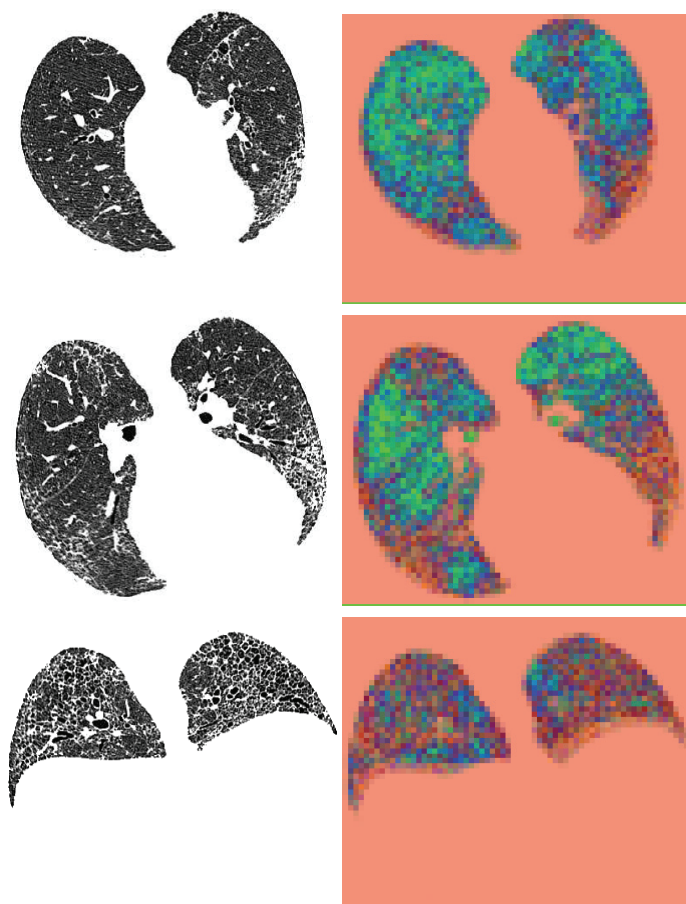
Results on axial HRCT slices of subject with severe pathology. Left column: original HRCT data. Right column: Results of PCA projection of first 3 principal modes of variation from covariance analysis of slice 30 (second row). Slices 20, 30 and 40 shown. Normal tissue colours as green; fibrosis colours as a blue-purple hue; honey-combing as brown and red.
